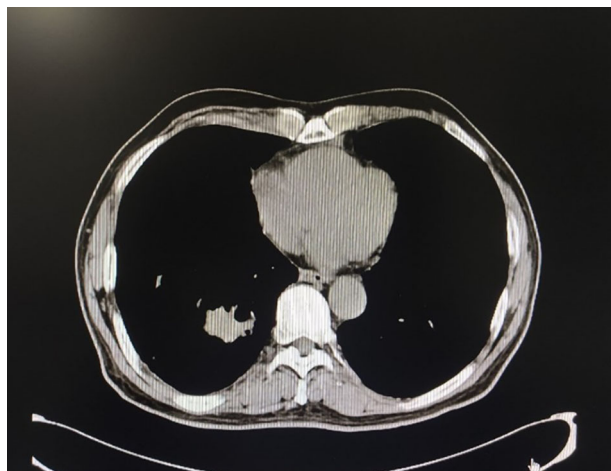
Chest CT one month after surgery.
